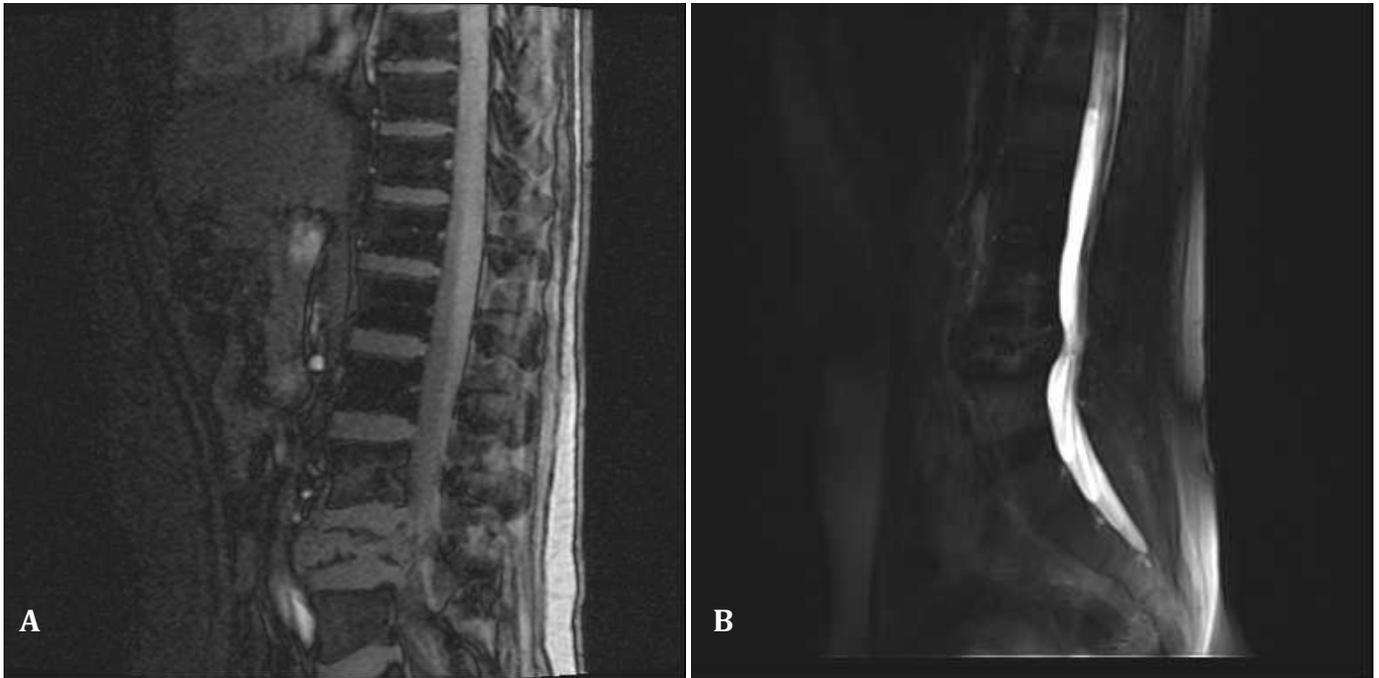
Magnetic resonance imaging of solitary plasmacytoma of bone in L4 vertebra. A) T1-weighted image showing a low to intermediate signal lesion with paravertebral extension. B) T2-weighted image showing a hyperintense lesion with significant bulging in the posterior of the body.
